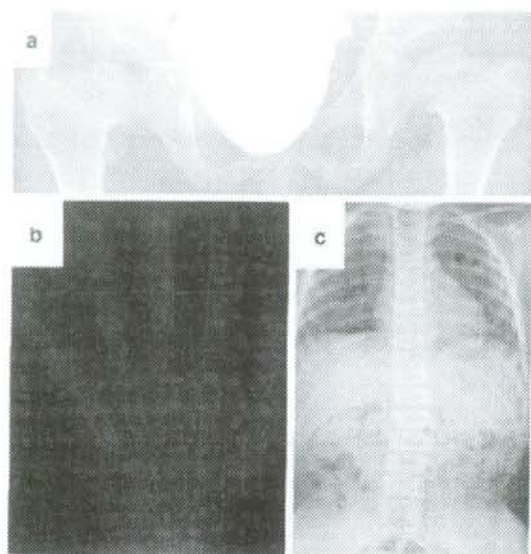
X-rays at 4 years of age. a Bilateral hip joints had acetabular dysplasia. Femoral heads were slightly flat and femoral necks were broad. As a result, coxa vara was displayed. b Carpal bone ossification was advanced; seven carpal bones were visible in this 4-year-old hand. c Total spine showed mild scoliosis and mild flattening of vertebrae
